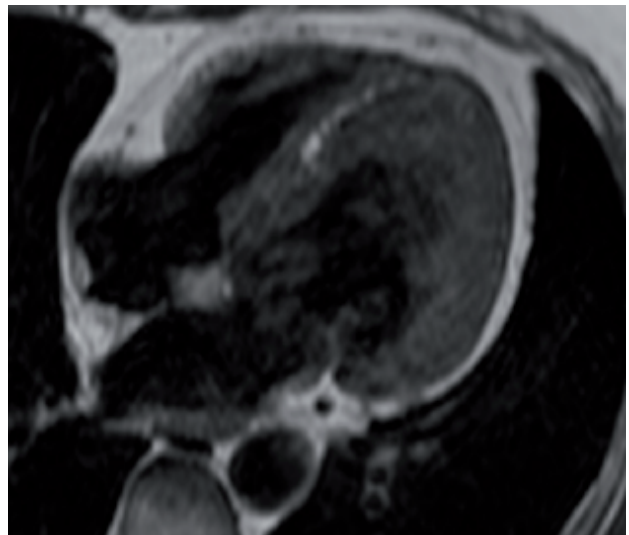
Cardiac magnetic resonance imaging, T1-weighted sequences. See explanation in the text.
